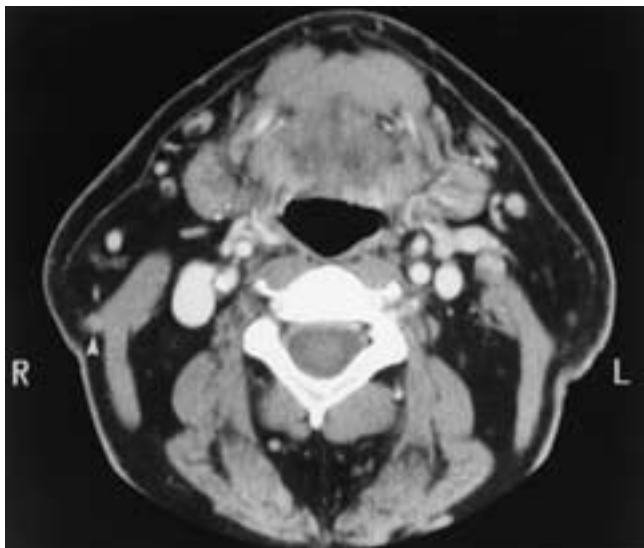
Recurrent cutaneous squamous cell carcinoma in the right lower parotid region with PNS along the great auricular nerve. Axial contrast-enhanced CT scan shows a subtly enhancing mass lateral to the right sternocleidomastoid muscle (arrowhead) representing PNS along the course of the great auricular nerve. (From Ginsberg LE, Eicher SA. Great auricular nerve: anatomy and imaging of perineural tumor spread. *AJNR* 2000;21:568–571.)
